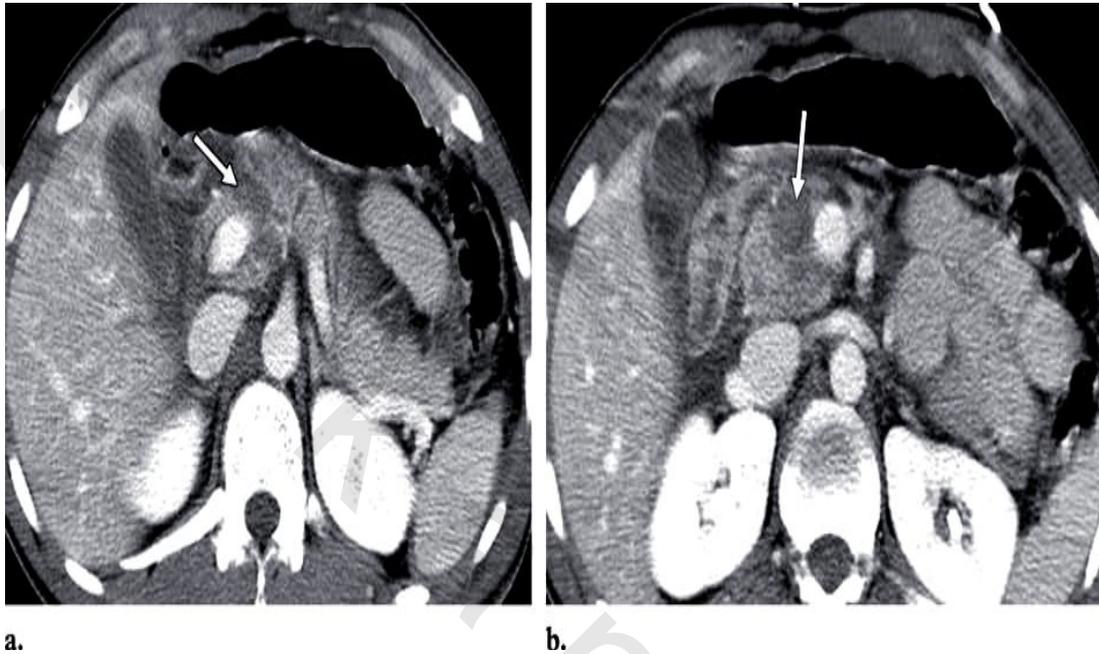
Abdominal CT scan with IV contrast (pancreatic transection). (a) At the level of the pancreas shows a full-thickness linear low-attenuation laceration of the pancreatic neck (arrow) just anterior to the proximal portal vein. (b) Inferior level of the pancreas to shows a focal hematoma at the transection site that extends into the pancreatic head (arrow).⁽⁵⁵⁾
